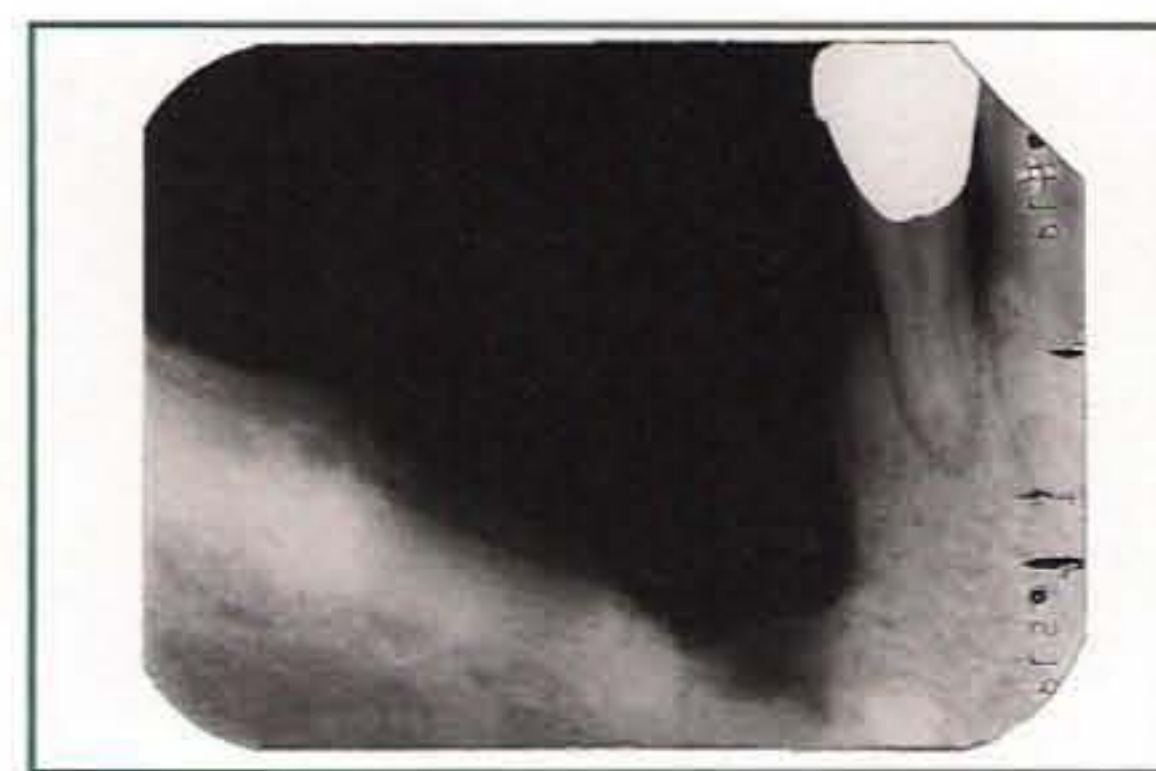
Intraoral radiograph showing the large vertical bone defect.
